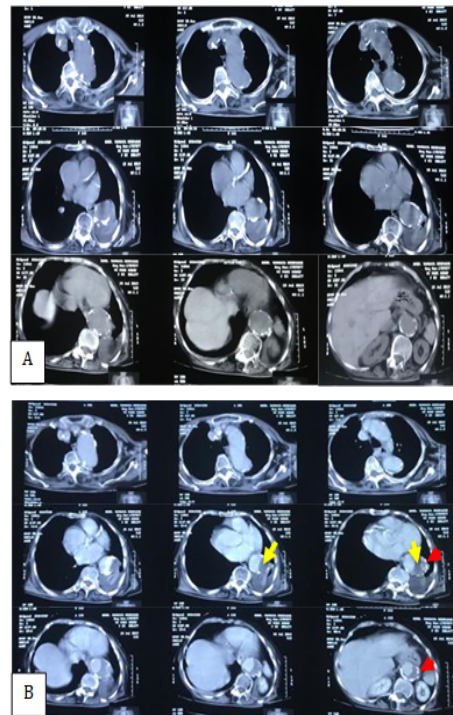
(A) Thoracic CT Scan: pre-contrast. (B) Thoracic CT Scan: post-contrast. Yellow arrow: radioluscent pattern showing intraluminal thrombus. Red arrow: showing irregularities of aneurysm wall.
